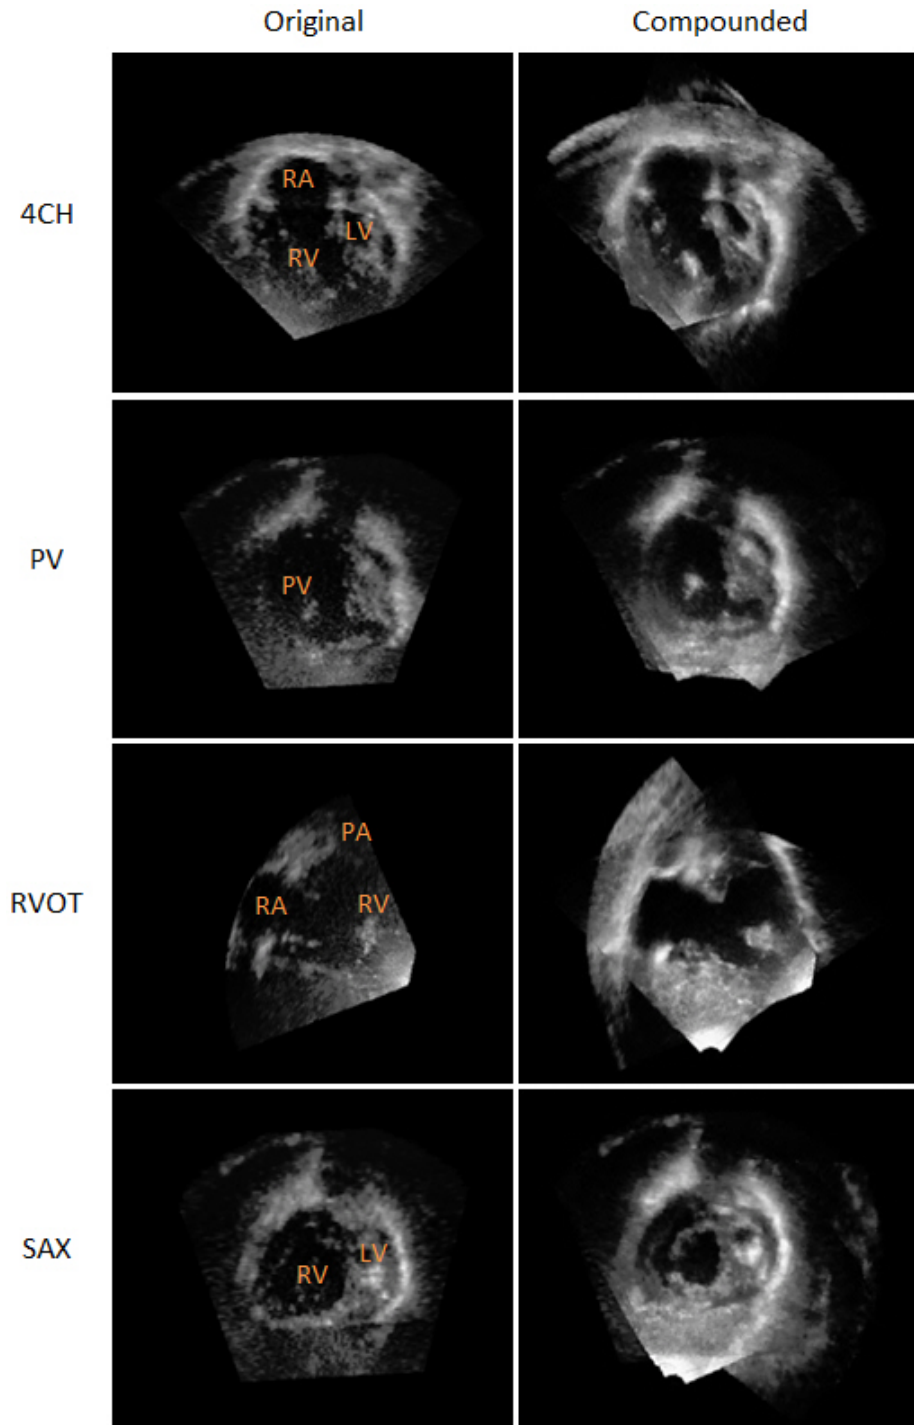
Slices from 3D echo images on HLHS5 patient data. Original and compounded images are presented in the following view angles: 4CH (apical four chamber), PV (pulmonary valve), RVOT (right ventricle outflow track) and SAX (short axis). My compounded images shows less noise, more contrast and with RV and PV well presented in single volume. (LV = left ventricle; RV = right ventricle; RA = right atrium; PA = pulmonary artery; EB = endocardial border)
